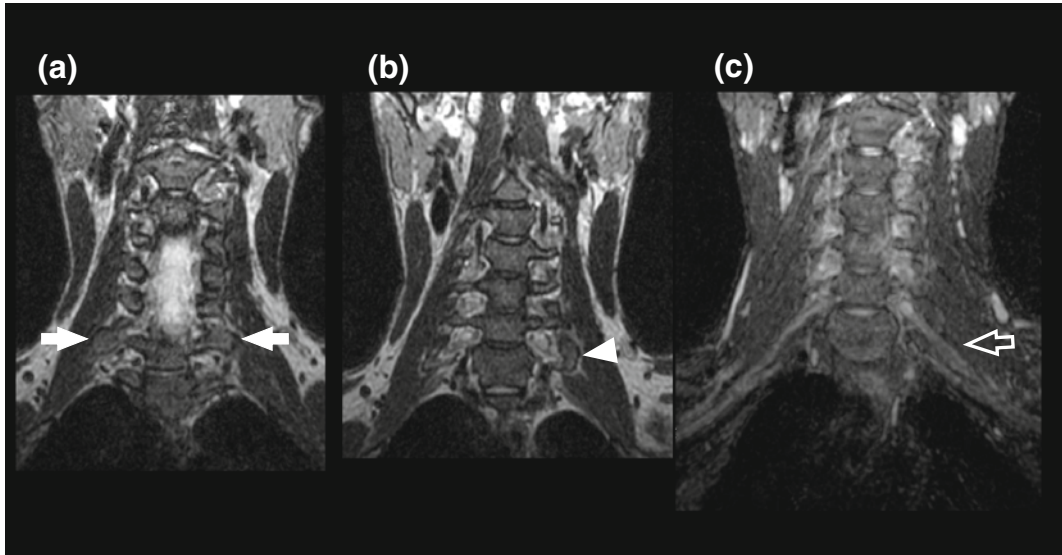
Thoracic outlet syndrome: MRN in a 14 years old boy with paresthesia of the *left* superior arm during sports activity. Sequence 3D IDEAL coronal T2-weighted (a), shows bilateral C7 prominent transverse process (arrows).
